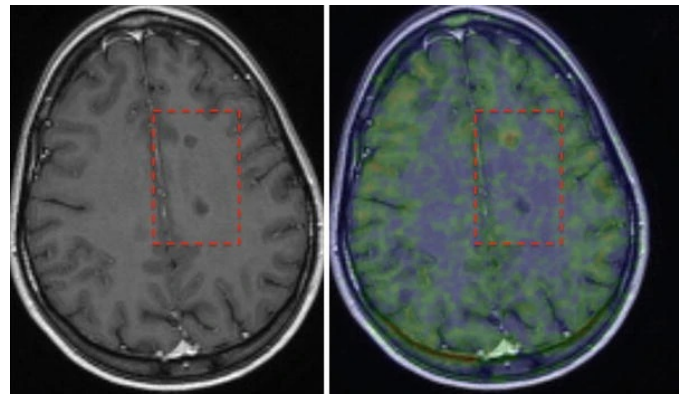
Left: A T1-weighted MRI image shows two similar-looking black holes outlined by a broken red line. Right: TSPO-PET shows high uptake in the chronically active lesion above and low uptake in the chronically inactive lesion below. Image source: (Airas et al. 2015), distributed under the Creative Commons CC BY license
